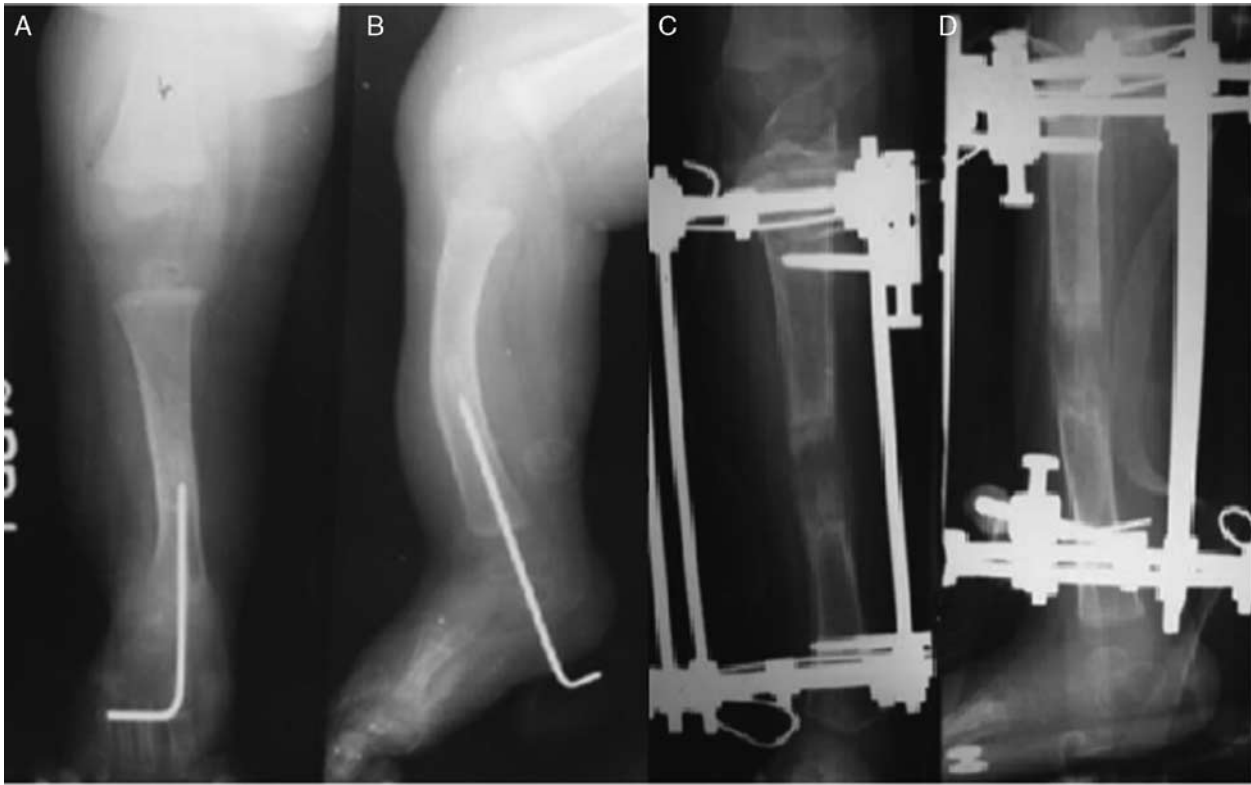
The deformity in Figure 6 was treated with partial resection of the fibular anlage, peroneal lengthening, and tendo-Achilles lengthening. An x-ray showing the anteroposterior (A) and lateral view (B) of the tibia, wherein a subtalar osteotomy was performed and fixed with k wires. Further treatment with lengthening using the Ilizarov method as an external fixator was performed. An x-ray showing regenerate callus formation at the corticotomy site in anteroposterior (C) and lateral views (D).
